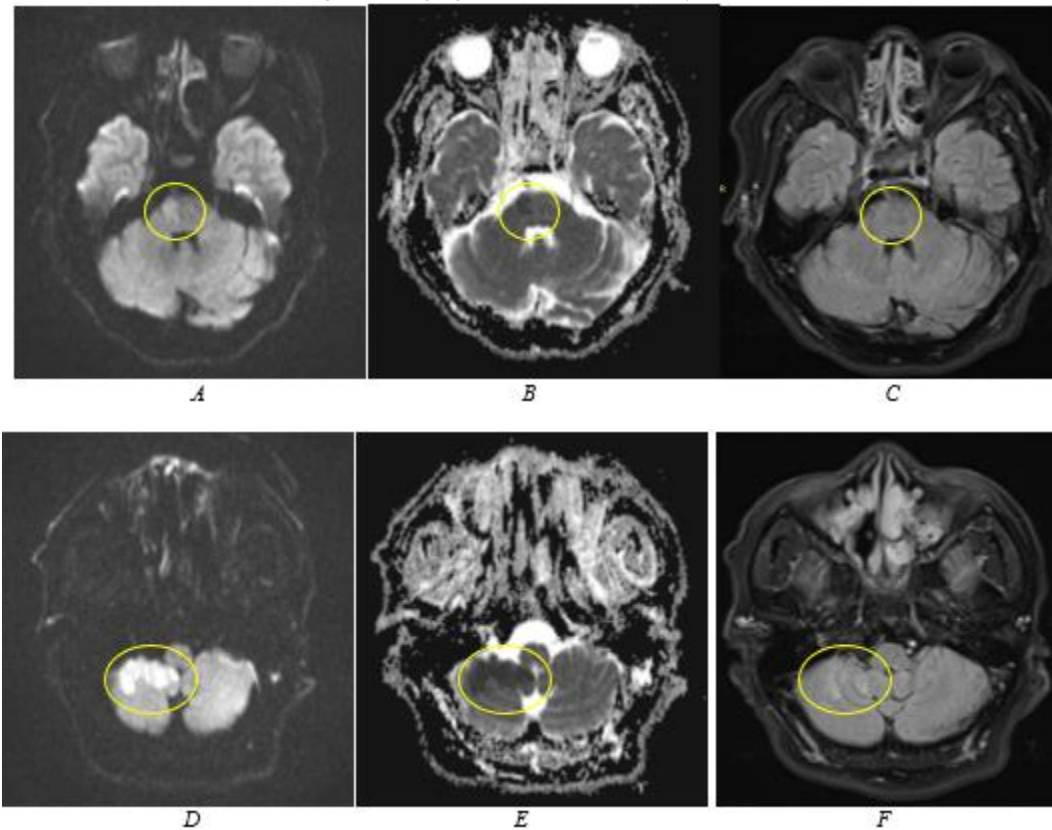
Areas of restricted diffusion with corresponding signal drop-out and DWI-FLAIR mismatch on the right hemispheres (A-C), and right inferior cerebellar hemisphere and tonsil (D-F)
